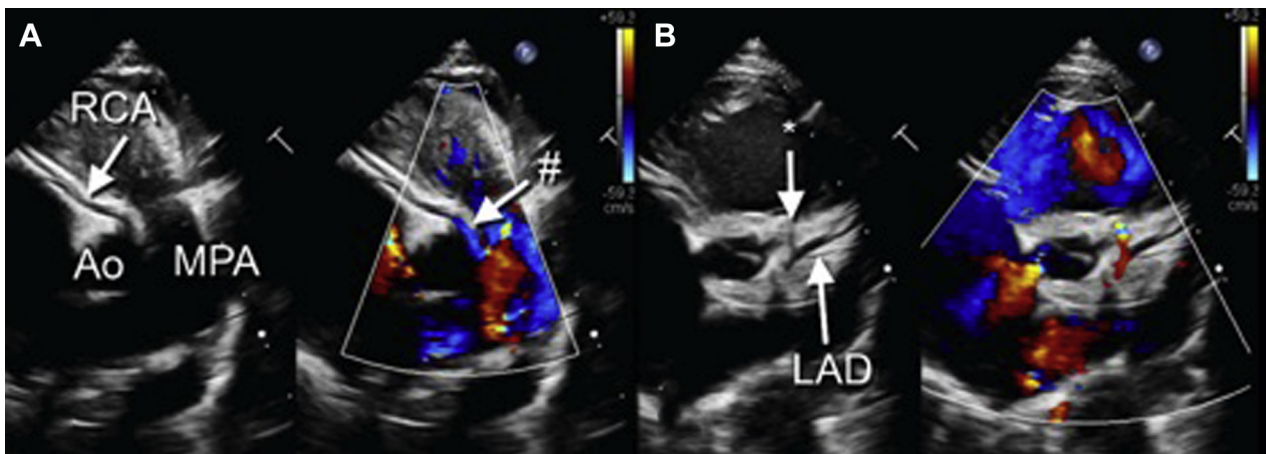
Preoperative transthoracic echocardiography with color Doppler imaging. (A) Flow reversal was noted across the right coronary artery; this was initially thought to be a possible right coronary artery (RCA)–to–main pulmonary artery (MPA) fistula. (B) Prominent left coronary artery with an additional branch initially suggestive of dual left anterior descending coronary artery (LAD) supply. Ao, Aorta.
